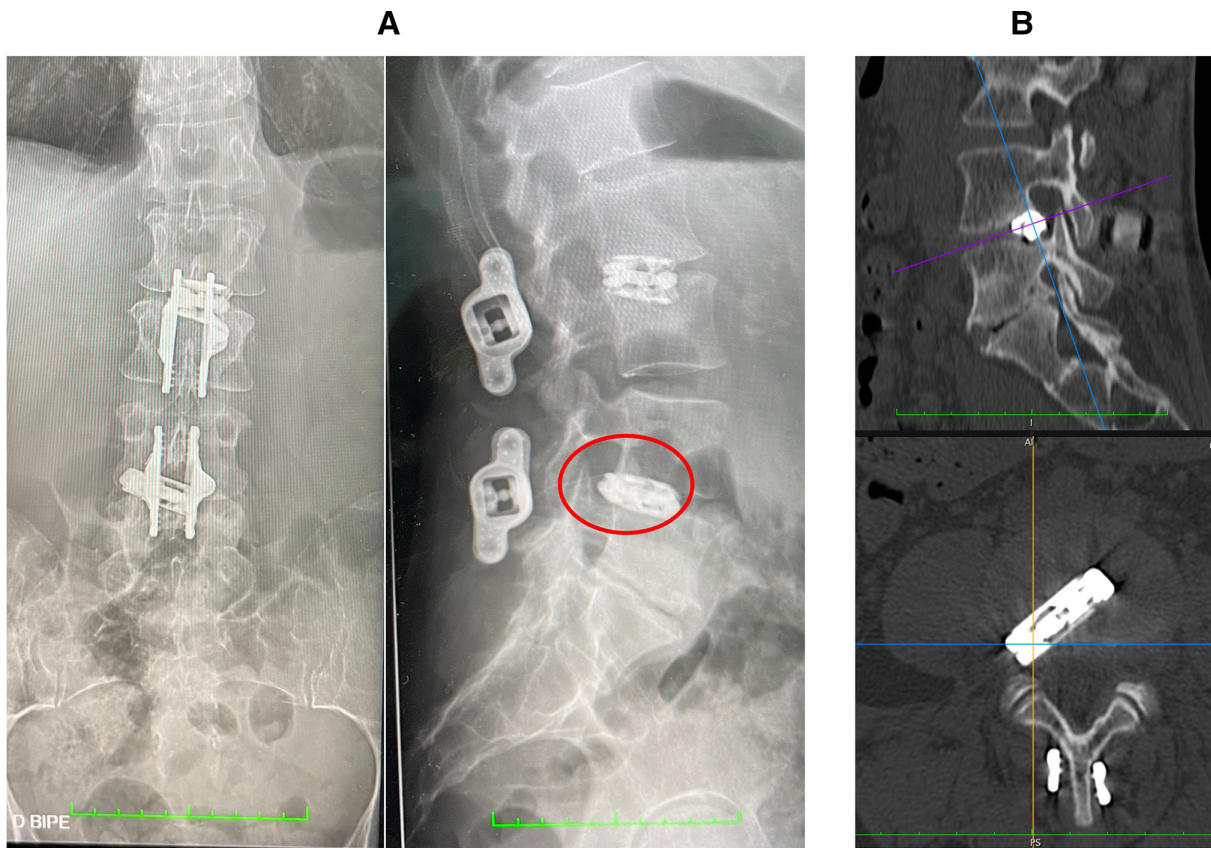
(A) Preoperative x-ray control images of the lumbar spine in anterior/posterior (left side) and lateral (right side) views for case 3. Notice the migrated interbody cage into the right neuroforamen of L4-L5 (marked with red circle). (B) Preoperative computed tomography image of the lumbar spine with lateral (above) and axial (below) views of L4-L5 showing a migrated interbody cage into the right neuroforamen of L4-L5.
